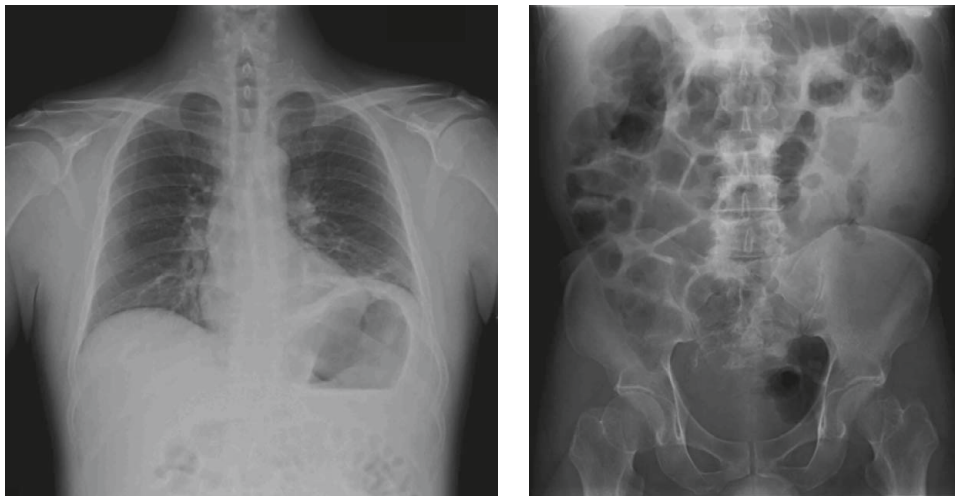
Chest and abdominal X-rays on admission showed no soft tissue lesion but only ileus and bowel gas.
